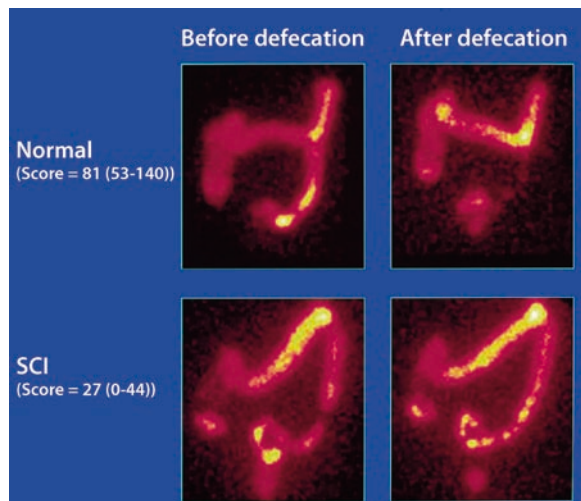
Colorectal scintigraphy after oral intake of isotopes. Scintigraphy in a healthy subject before (*top left*) and after (*top right*) defecation, showing emptying of 81% of the contents of the rectosigmoid. Scintigraphy in a patient with disturbed defecation due to a traumatic lesion of the cauda equina before (*bottom left*) and after (*bottom right*) defecation, showing emptying of 27% of the content of the rectosigmoid
